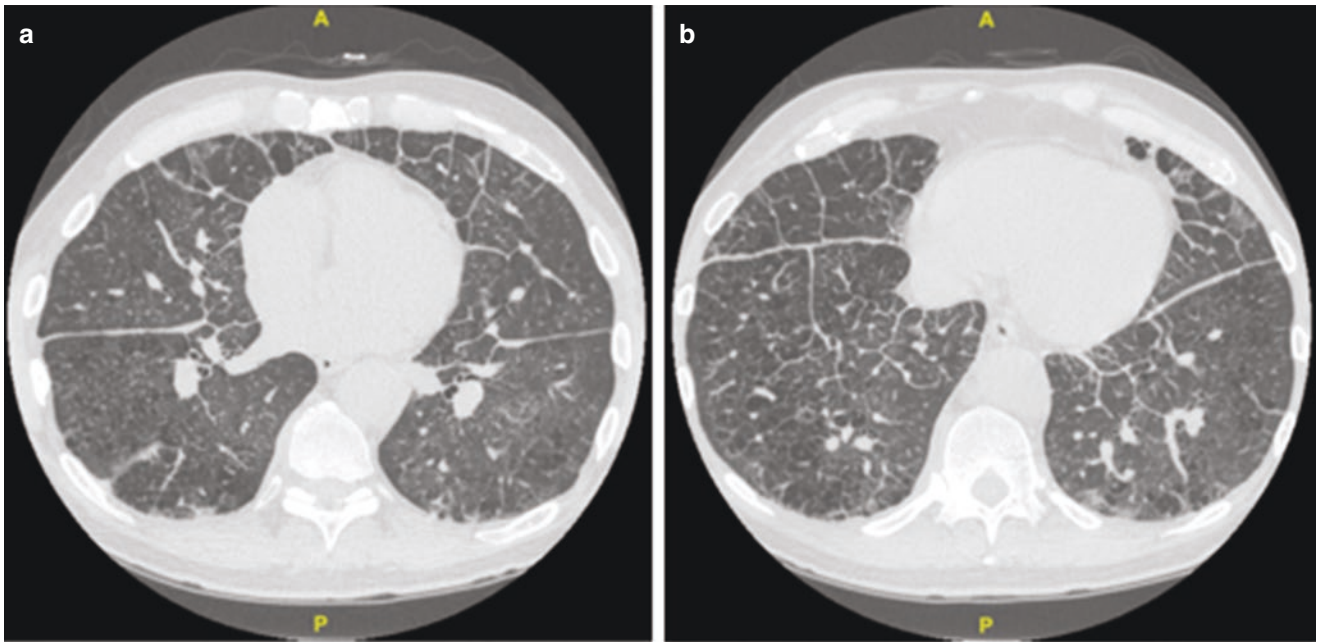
Characteristics of chest HRCT. (a), (b) HRCT show inter- and intralobular septal thickening throughout the lungs and diffuse ground-glass opacities superimposed in a background of paraseptal and centrilobular emphysema
